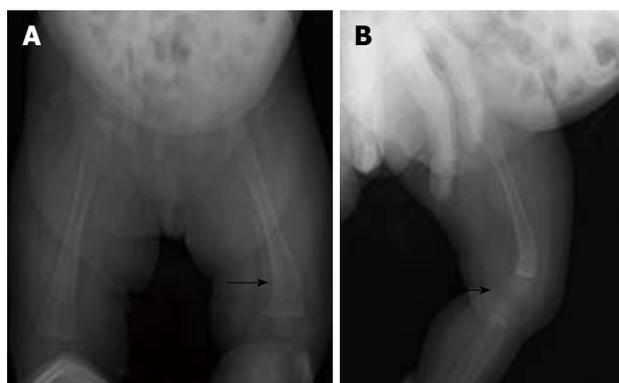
Plain skeletal radiographic features at the 28 d after hepaticojunostomy in the case 2. Anteroposterior (A) and lateral (B) plain radiographs showing a displaced fracture (arrows) of the left distal femur.
